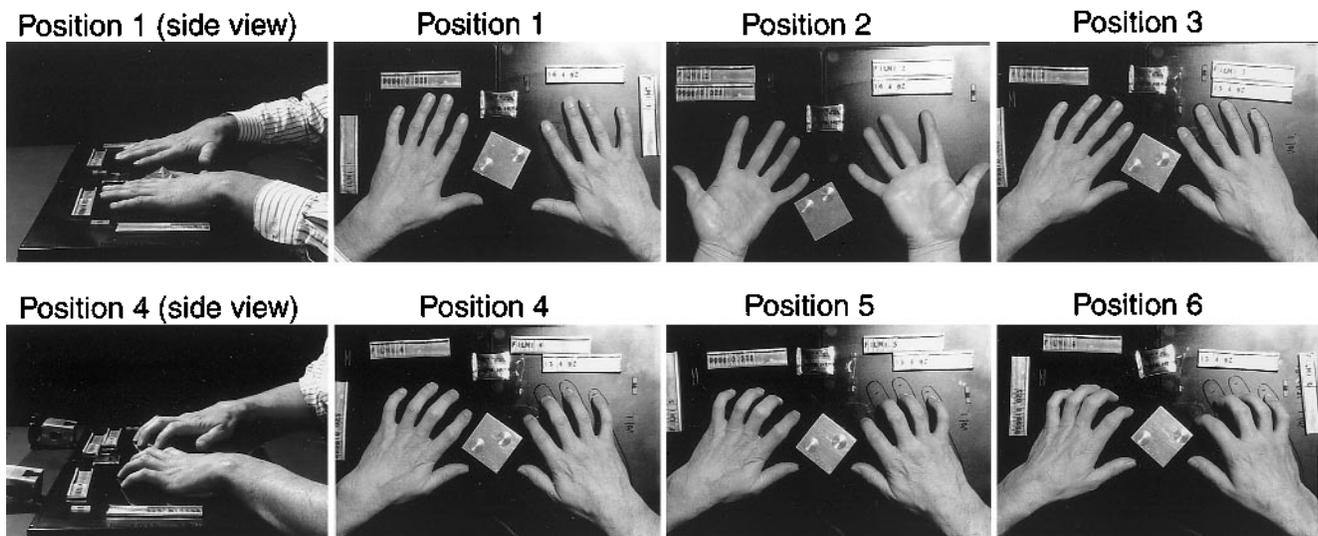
The 6 different hand and wrist positions radiographed in the Position Study. The hands were placed on paired film cassettes. Position 1 corresponds to the hand position used in the Repeat Study. In position 3, the fingers were outlined on a clear plastic film template. Marks for the fingers flexed 1/3 (Position 4) and 2/3 (Positions 5, 6) can be seen. Also shown are identifiers, a reference density step wedge, and thermoluminescent detectors used to assess exposure to ionizing radiation.
